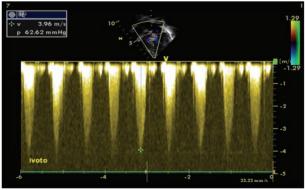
2D Doppler (Apical 4 Chamber) Showing Severe Left Ventricular Outflow Obstruction (Peak Gradient>62mmHg) due to Accessory Mitral Tissue
